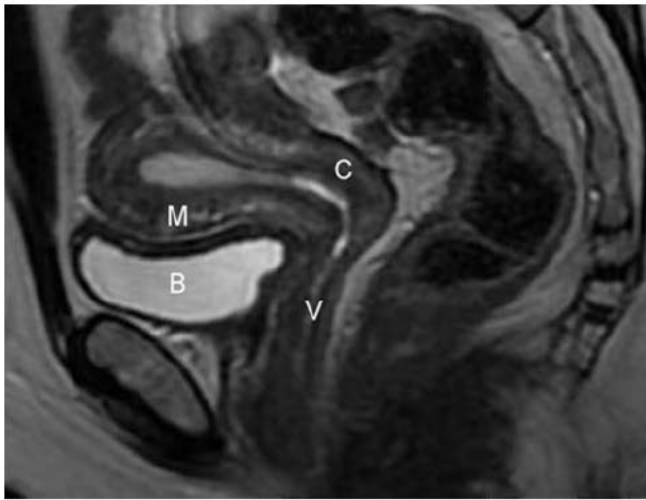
Sagittal T2-weighted magnetic resonance (MR) image of a normal uterus and cervix (C). B = bladder; M = myometrium; V = vagina.
